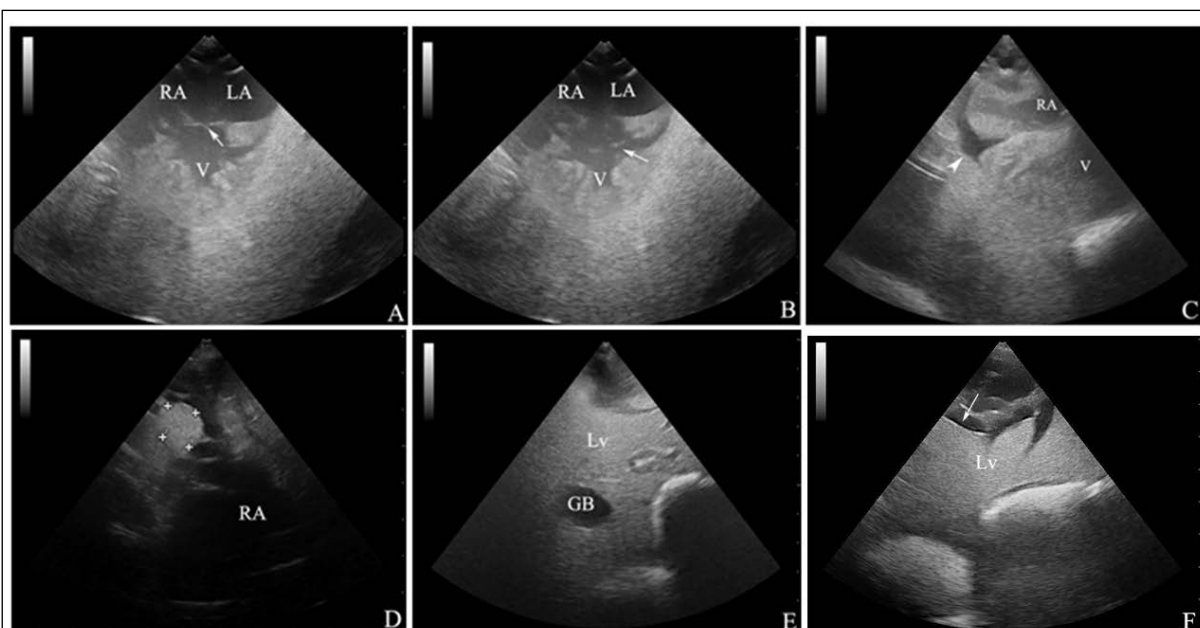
Ultrasonographic image of the heart, thyroid and liver tortoise viewed through the right and left cervical windows. A) Atrium and ventricles filled with hypoechoic content. The ventricle shows trabecular wall and the atrioventricular valves are closed (arrow). B) Atrioventricular valves open (arrow). C) The atrium shows projections of the inner surface. It is possible to visualize fluid around the heart (arrow head). D) Thyroid hyperechoic oval in shape with well-defined limits. E) Liver with hyperechoic granular texture and rounded gallbladder with anechoic content and posterior acoustic enhancement. F) Free fluid anechoic (arrow) among hepatic lobes showing tapered edges and regular margins. V, Ventricle; RA, Right atrium; LA, left atrium; Lv, Liver; GB, Gallbladder.
